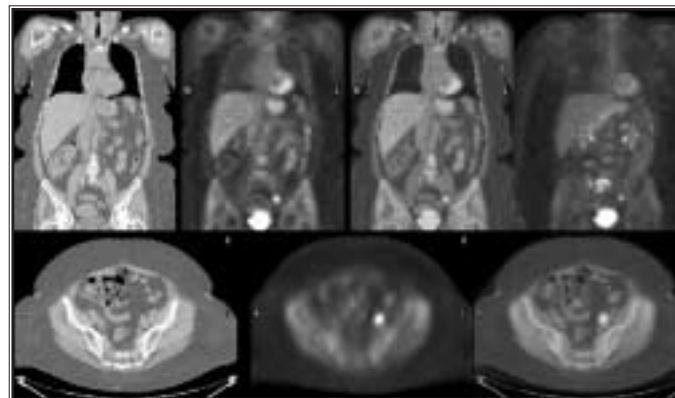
49-year-old woman with newly discovered carcinoma of the cervix thought to be localized to the cervix on both physical exam and CT. Top row: Coronal CT, PET, fused, and MIP images. Bottom row: Transverse CT, PET, and fused images. In addition to demonstrating the primary tumor immediately rostral to the bladder, PET reveals a metabolically active left external iliac lymph node less than 1 cm in diameter. Radiation treatment planning field was extended to include this otherwise occult metastasis, and follow-up scan revealed complete response.
